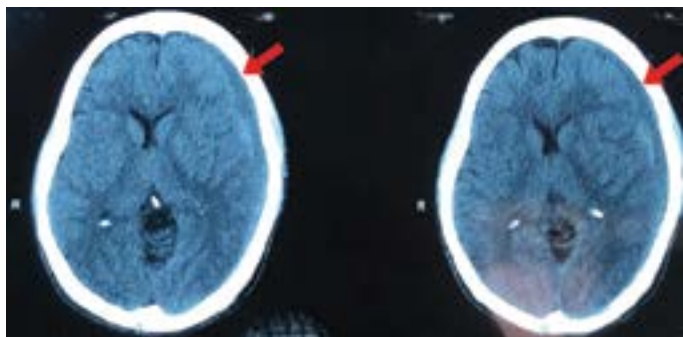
Plain CT scan of the brain showing Spontaneous Subacute Fronto-Temporal Subdural Hematoma marked with a red arrow.
